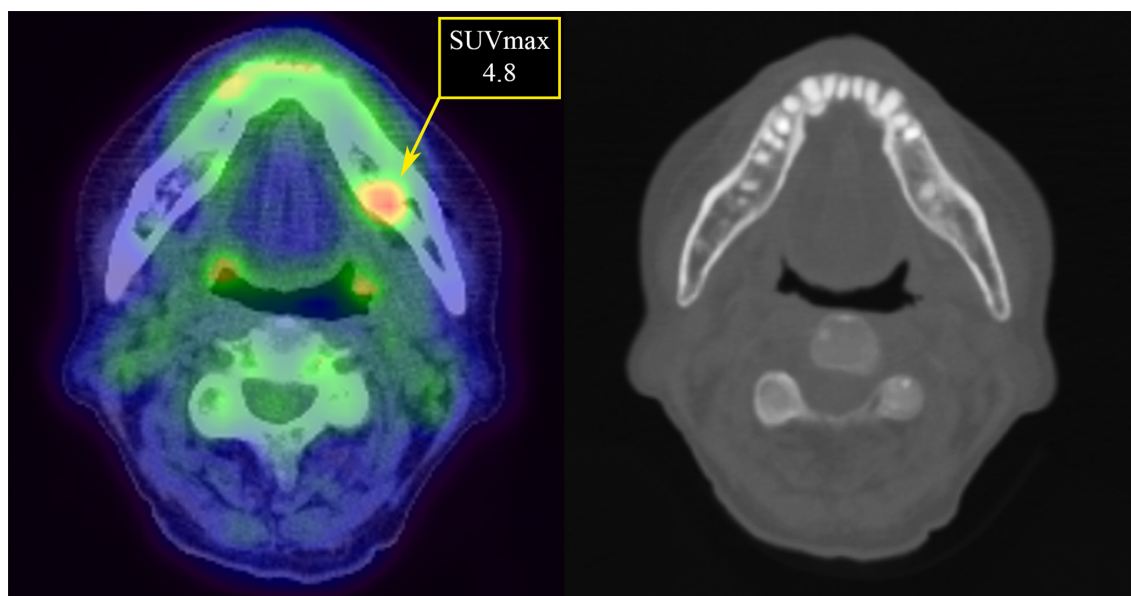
A 68-year-old male with Stage 0 MRONJ with a history of lung cancer and multiple metastases. FDG PET/CT images of the patient show an increased uptake at 4.8 of SUV_{max} at the left mandibular area indicating underlying inflammation or a potential site for developing MRONJ. In this case, clinical bone exposure occurred one month after FDG PET/CT examination. FDG, fludeoxyglucose; MRONJ, medication-related osteonecrosis of the jaw; PET, positron emission tomography; SUV_{max} , maximum standardized uptake value.
